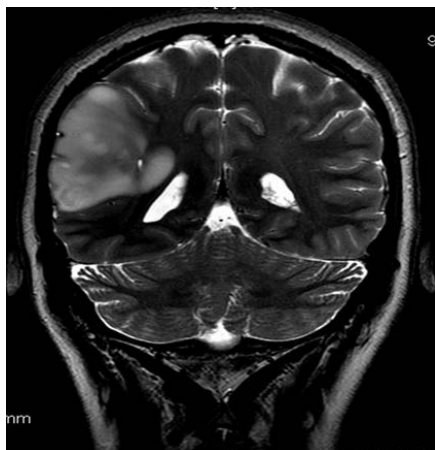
Head magnetic resonance imaging shows a tumor in the right parietal lobe of the brain.
